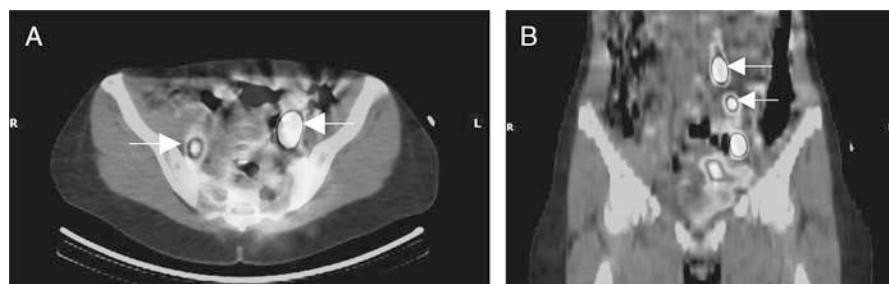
SPECT/CT scan with hot spots bilateral iliac (A), left para-aortic and left common iliac identified as SLNs (B).
